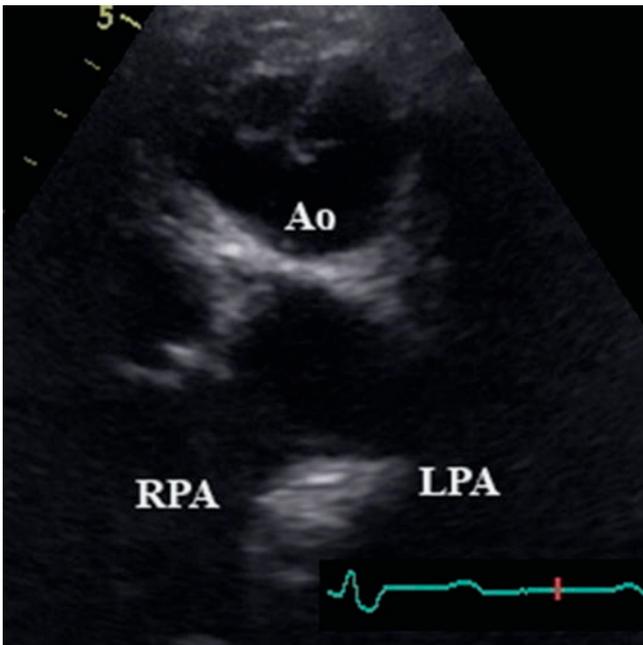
ccTGA short-axis view. High parasternal short-axis view in a patient with congenitally corrected transposition of the great arteries. The aorta (AO) is seen anterior and slightly leftward of the pulmonary artery, which is posterior and branches into the left (LPA) and right (RPA) pulmonary arteries
